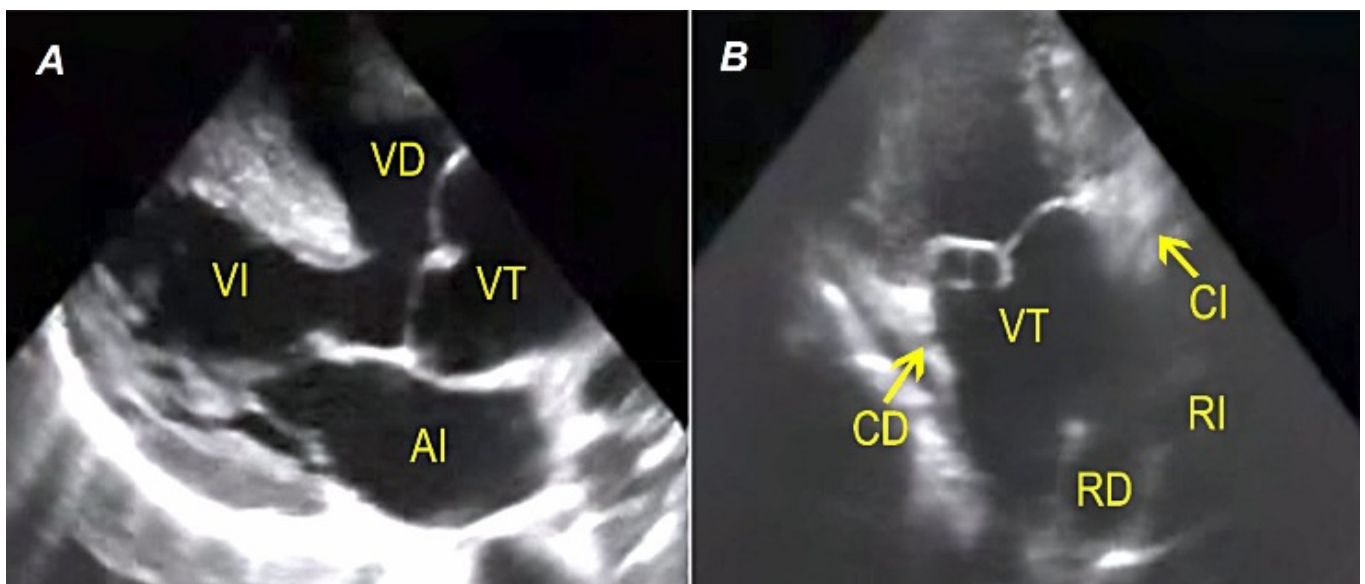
A. Parasternal long axis view, where the truncal vessel overrides the large conoventricular ventricular septal defect. B. (Persistent truncus arteriosus, type I) Pulmonary arteries originating from the left posterolateral wall of the truncal vessel by a short pulmonary trunk, right and left coronary arteries emerging from right and left coronary sinuses. Acronyms in Spanish - AI: left atrium, CD: right coronary artery, CI: left coronary artery, RD: right pulmonary artery, RI: left pulmonary artery, VD: right ventricle, VI: left ventricle, VT: Truncal vessel.
